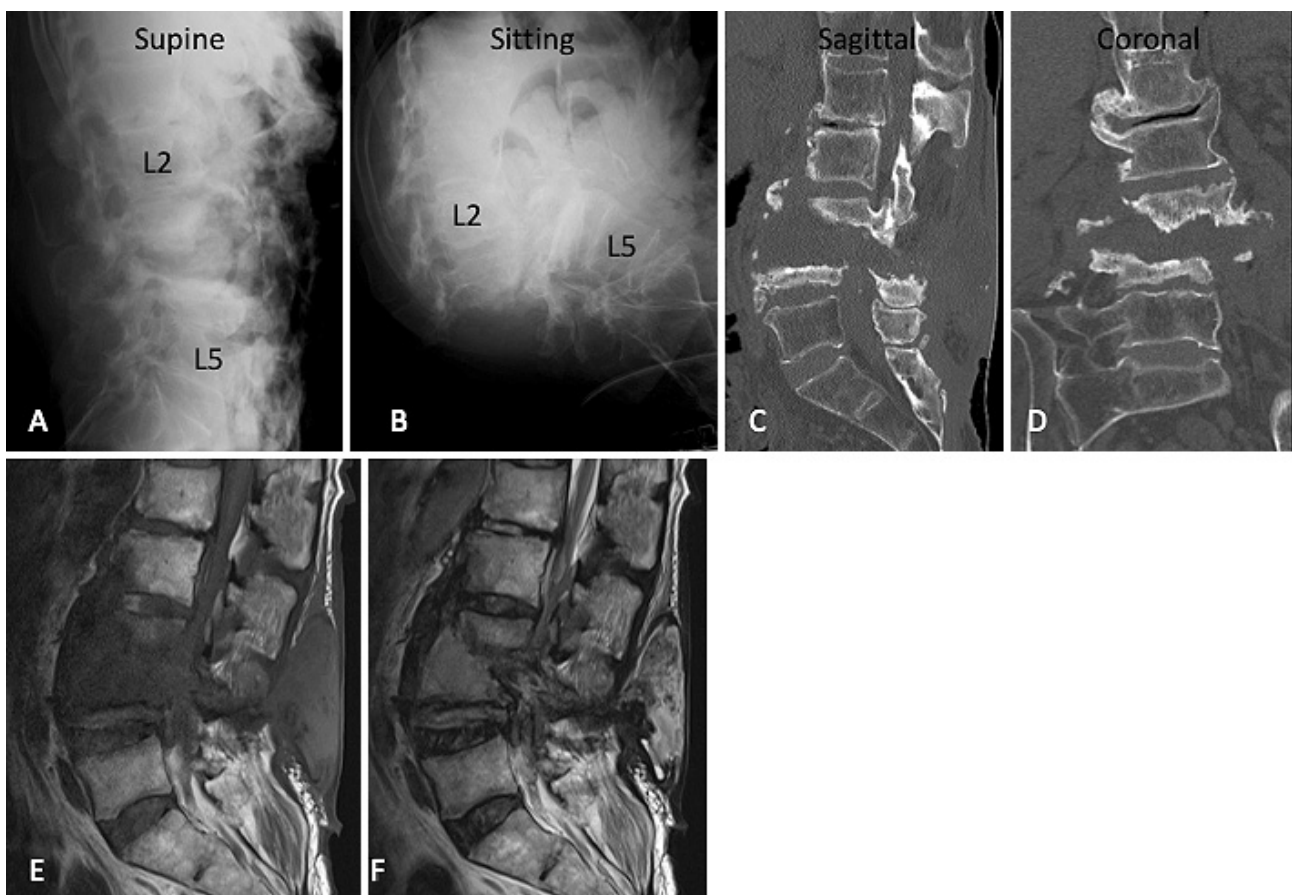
A, B. Significant instability was seen on the X-ray. C, D. Bone destruction accompanied by osteosclerosis of the vertebral body was observed in L3-L4 on CT. E, F. Low- and high-intensity area in T1- and T2-weighted sagittal images that continued from the L3-L4 intervertebral disc to the posterior mass was seen on MRI.
